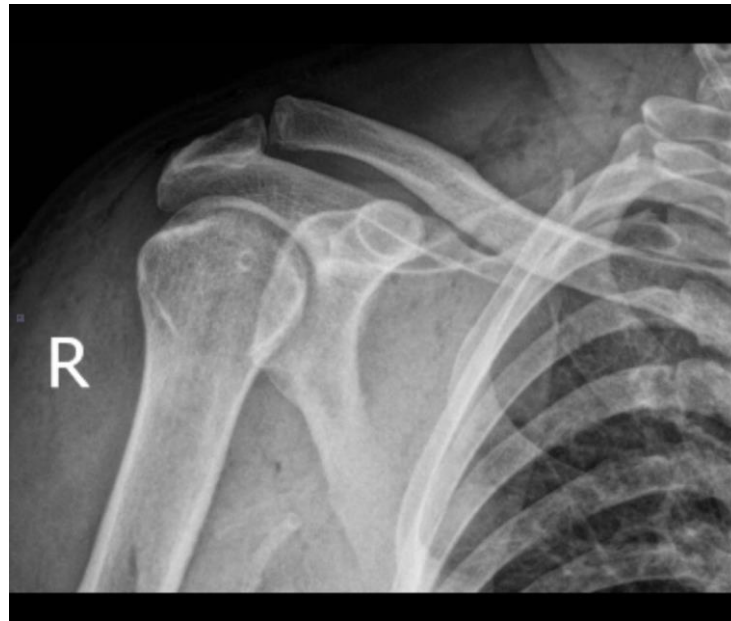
Post-reduction radiograph showing a concentric reduction of the shoulder joint
